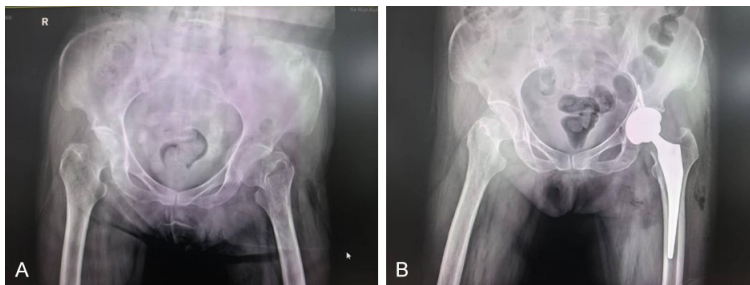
A: X-Ray pre-operation. B: Post-operation.
